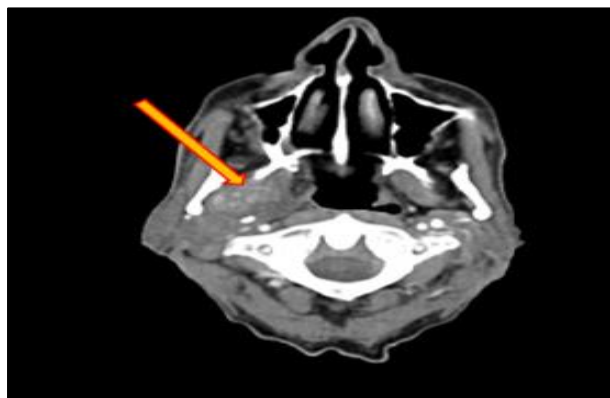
CT Head and neck showing enlarged right parotid gland with mandibular lymphadenopathy.
